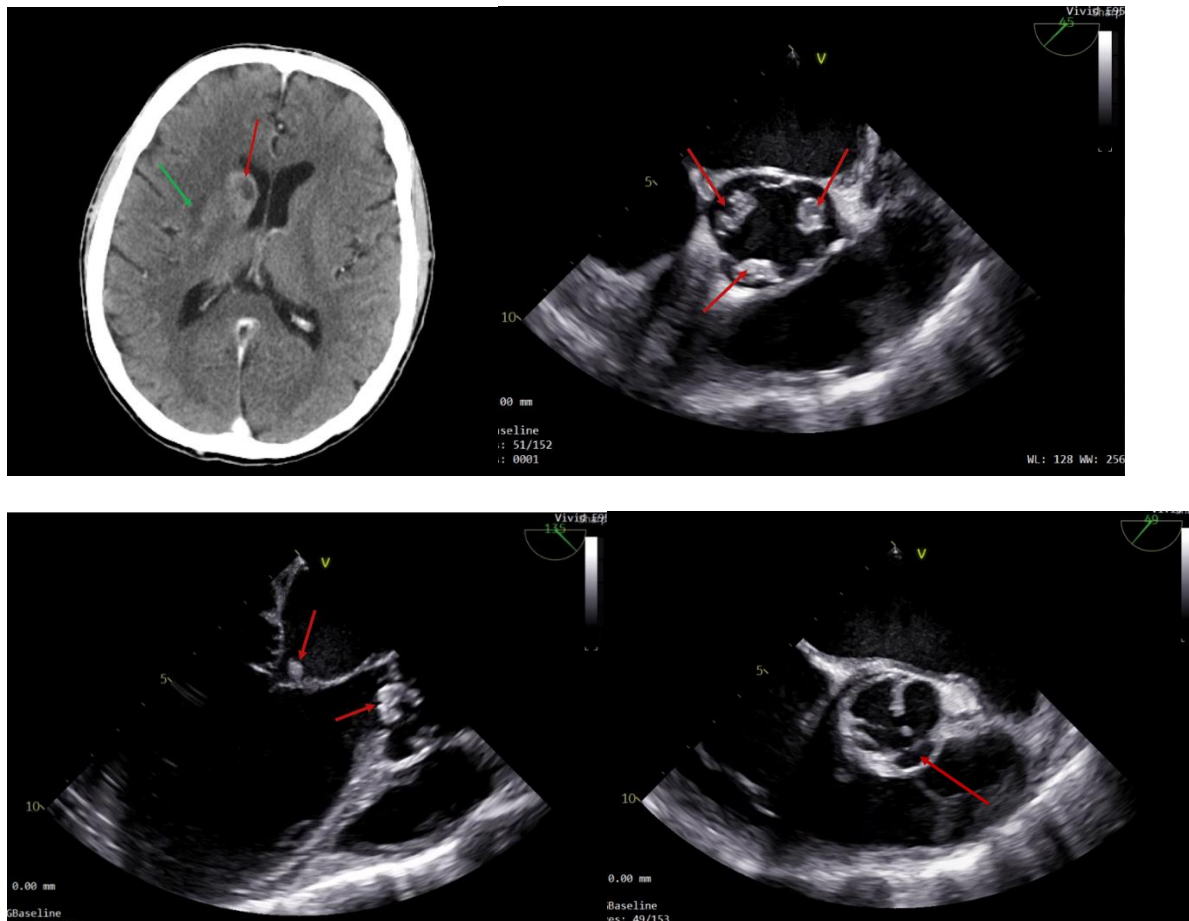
A – Contrast-enhanced computed tomography scan of the head- edema (red arrow) and scar tissue (green arrow); B –vegetations on the aortic valve mid-esophageal short-axis view, transesophageal echocardiogram (TEE) (red arrows); C – vegetations on the aortic valve and the anterior mitral leaflet mid-esophageal long-axis view, TEE (red arrows); D – cavity after drainage of the abscess mid-esophageal short-axis view, TEE (red arrow)
